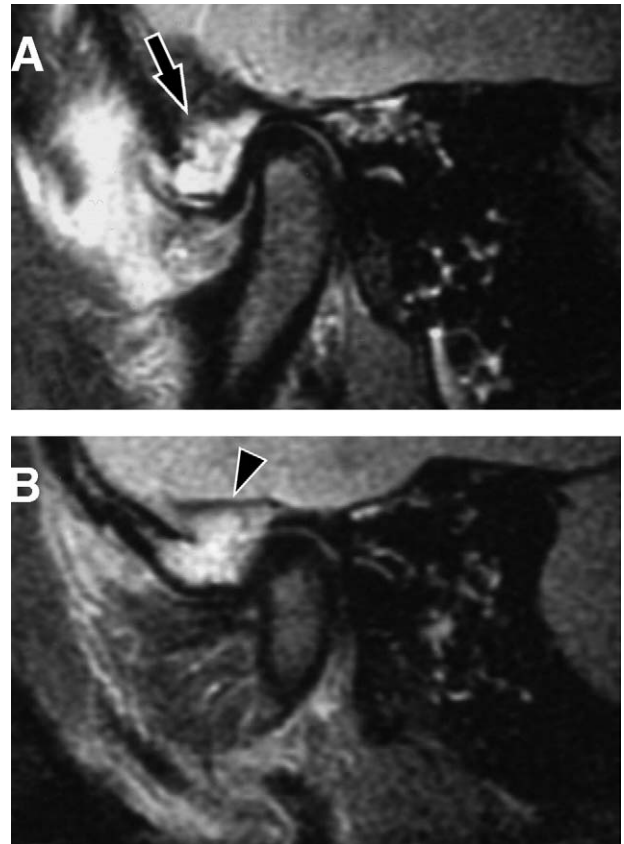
The T2-weighted MR image shows high-intensity lesion in the right articular eminence. Fracture of the articular eminence (A, arrow) and glenoid fossa (B, arrowhead) is suspected.
